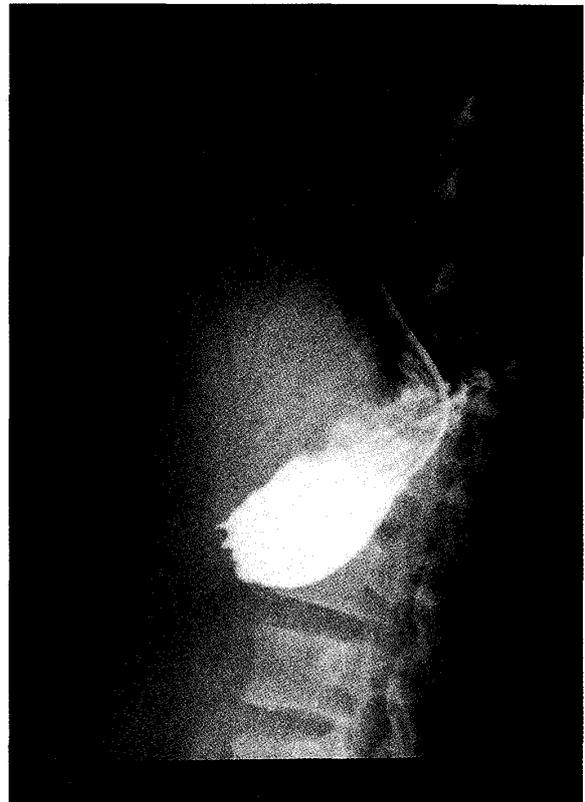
Barium X-ray examination of the stomach (the 63rd day)
